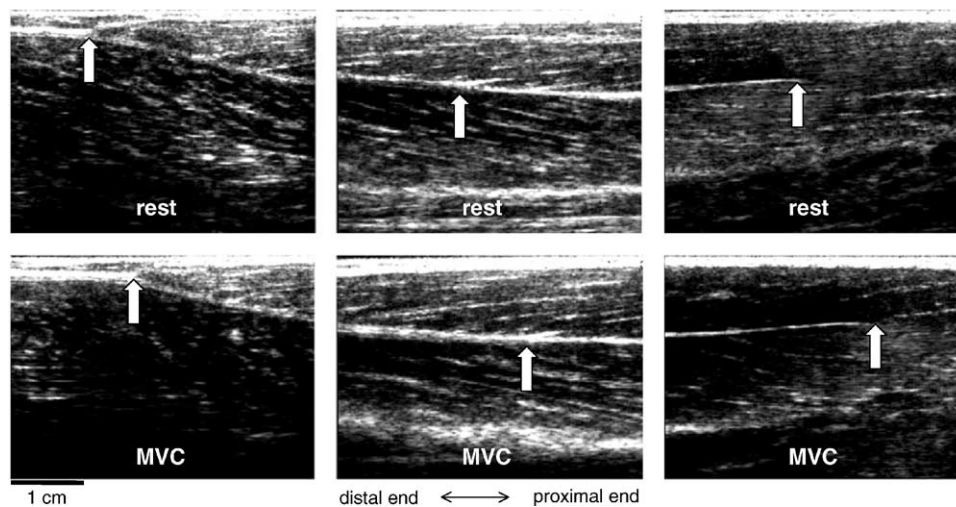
Typical sonographs over the TA muscle-tendon unit at rest and during isometric dorsiflexion MVC. The arrows point to the reference points identified, i.e., the TA tendon origin (left), the intersection between a central fascicle and the central aponeurosis (middle), and the aponeurotic proximal end (right). All three reference points shift proximally during contraction (from Maganaris and Paul, 2000c).
